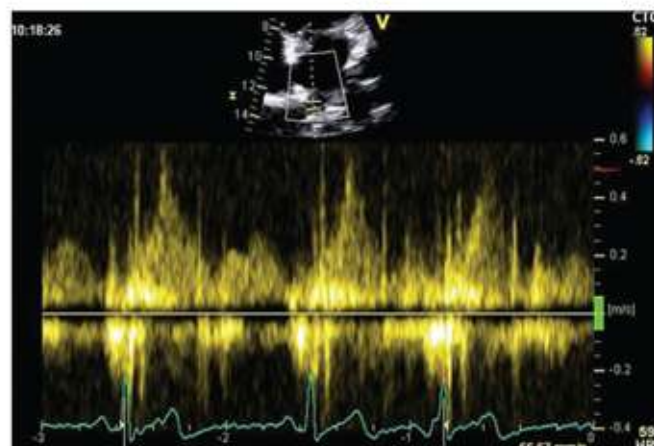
Pulmonary venous flow into the left atrium seen on pulsed-wave Doppler
